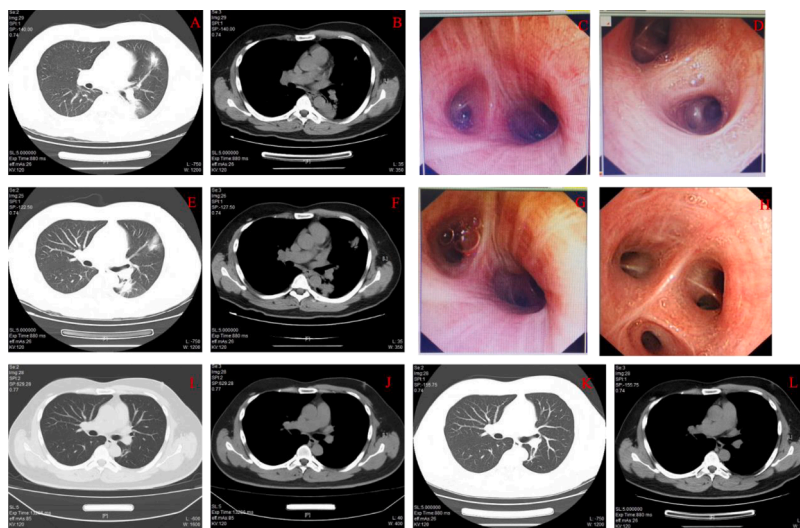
Chest CT scan and bronchoscopy examination of the patient. (A-B) On August 17, 2023, the pulmonary window and mediastinal window display multiple lesions in the dorsal segment of the right lower lung lobe, the superior lingual segment of the left upper lung lobe, the dorsal segment of the left lower lung lobe, and the posterior and lateral basal segments of the left lower lung lobe. (C-D) On August 21, 2023, inflammatory changes in the left upper lobe bronchitis. (E-F) About half a month, the pulmonary and mediastinal windows depict a slightly enlarged lesion area in the anterior segment of the left upper lobe, with an increase in solid components. (G-H) Inflammatory changes in the left upper lobe bronchitis. (I-J) Three month later, the pulmonary window indicates that the lesions in the lingual segment and lower lobe of the left lung have decreased less than before, with a small amount of fibrous foci in the apicoposterior segment of the left upper lung lobe. The mediastinal window appears normal. (K-L) On May 2, 2023, the pulmonary window indicates that the lesions in the left lung have been absorbed, and the mediastinal window appears normal.
